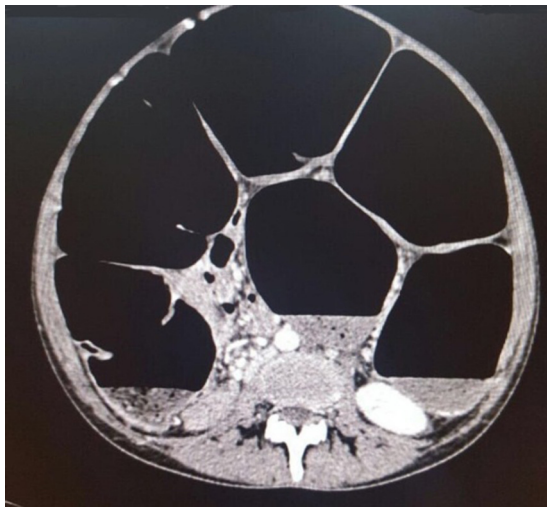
CT Abdomen showing Sigmoid Volvulus with Steel pan pattern.
